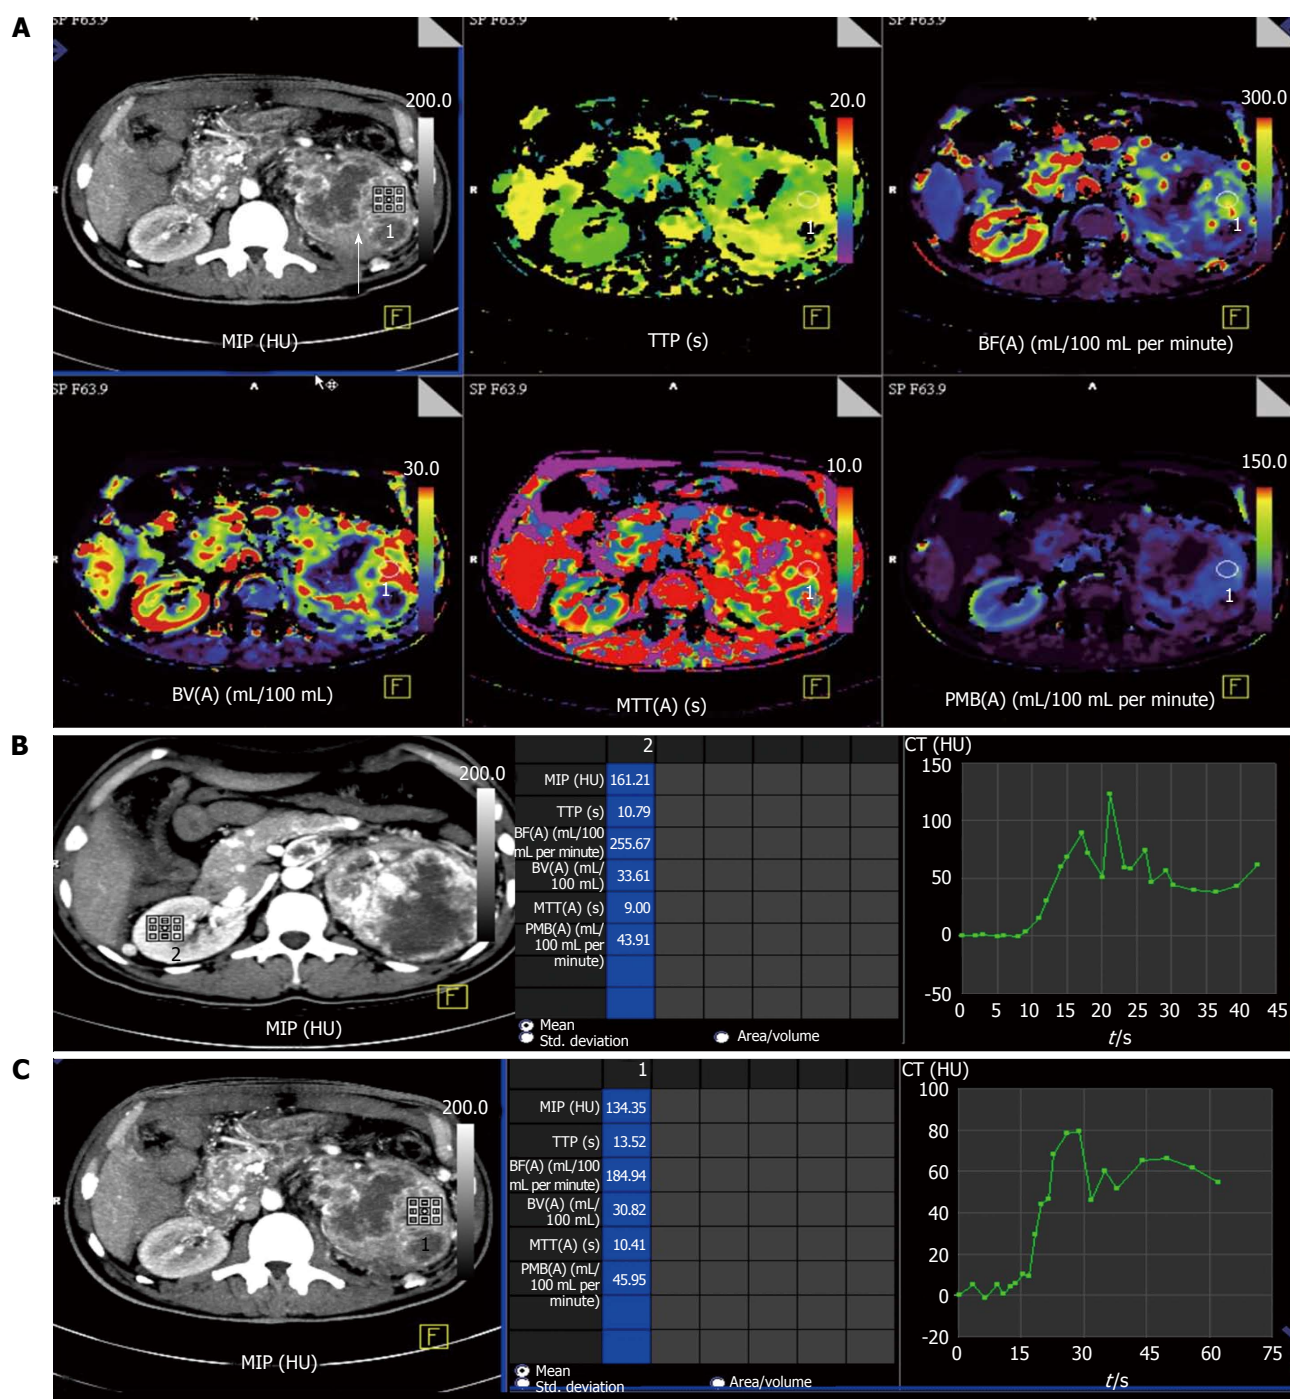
Perfusion computed tomography in normal renal parenchyma vs renal cell carcinoma in a 50-year-old man with left renal cell carcinoma (clear cell type). A: Contrast computed tomography (CT) images showed a large, hyperenhancing mass in left kidney with central necrosis (arrow). Colour-coded perfusion maps show various perfusion parameters in normal right kidney and diseased left kidney. Red being the region with highest perfusion parameter with purple being the least; B: Time attenuation curve and the perfusion parameters in normal right kidney. Normal renal parenchyma is seen to have high perfusion in the range of 255 mL/100 mL per minute; C: Time attenuation curve and perfusion parameters in the left renal cell carcinoma. There is delayed wash-out of contrast in the region of the tumour as depicted in the graph. MIP: Maximum peak intensity; TTP: Time to peak; BF: Blood flow; BV: Blood volume; MTT: Mean transit time; PMB: Permeability.
